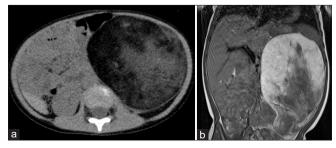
Computed tomography scan revealed a well-circumscribed, heterogeneous, and fatty mass (a). Magnetic resonance imaging con>rmed a multilobulated mass suggestive of a lipomatous tumor of retroperitoneal origin (b)
